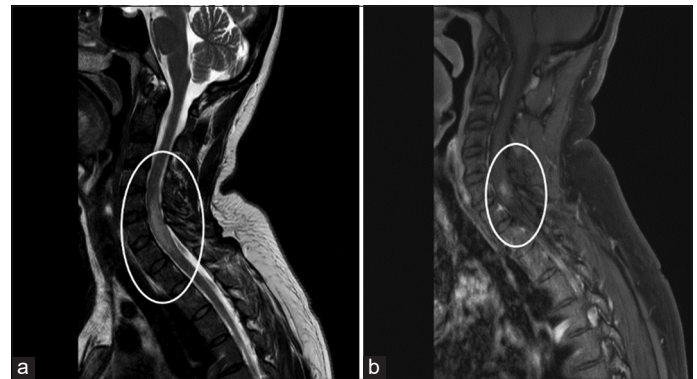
Magnetic resonance imaging spine sagittal section T2 sequences showed a long segment of hyperintensity (a) in the cervical spinal cord with contrast enhancement (b)
